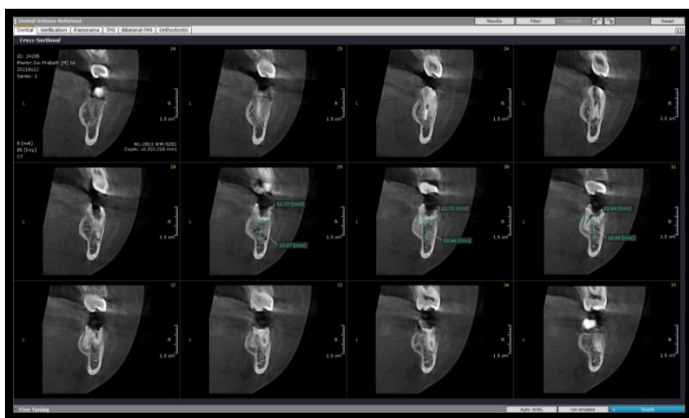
CBCT showing the exact position of separated instrument
